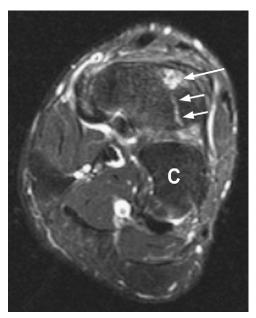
Coronal T2-weighted fat-suppressed magnetic resonance image in 29-year-old marathon runner. There is a stress injury close to the dorsal cortex of the navicular bone (long arrow) with a vertical fracture-extending inferior toward the plantar cortex (short arrows). Note the lack of surrounding marrow edema. Radiograph was negative. C=cuboid.
